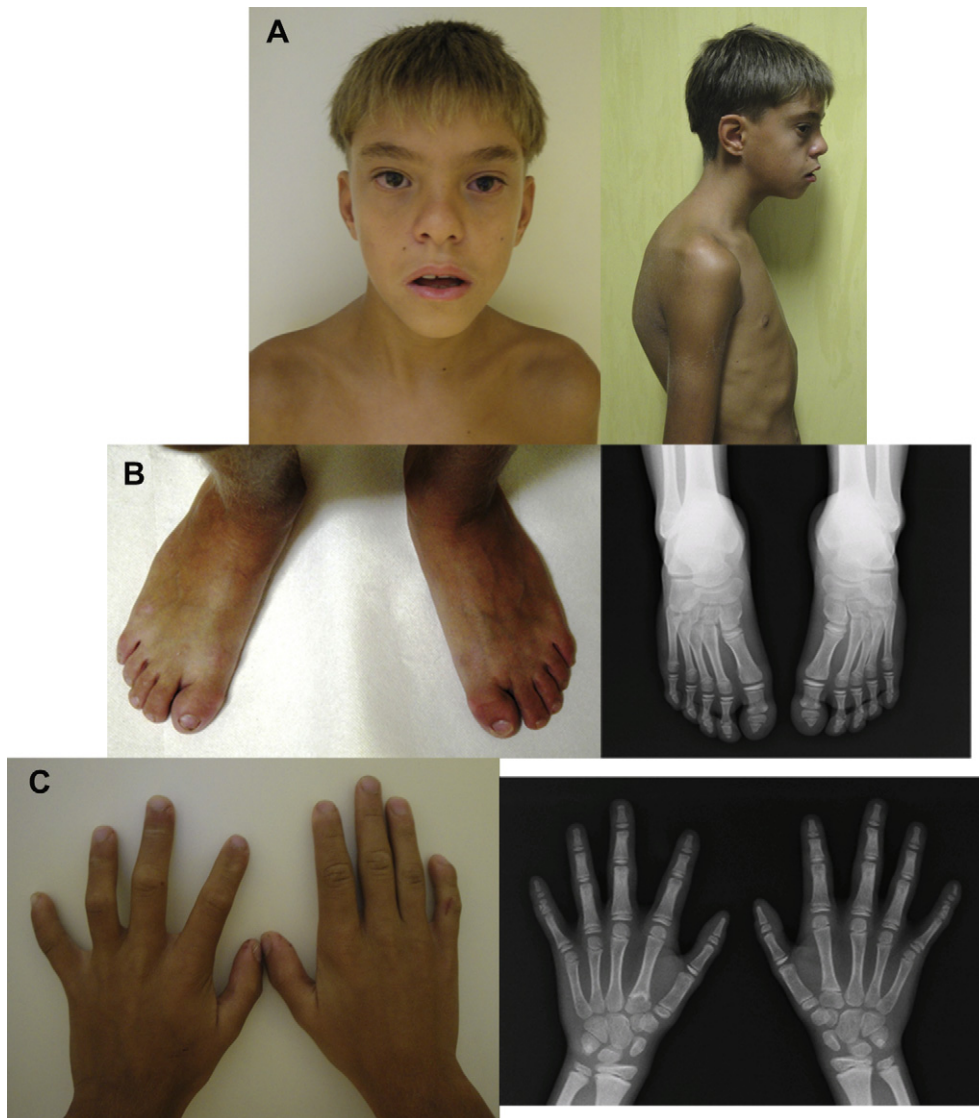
A: Face with upward slant of palpebral features, narrow palpebral fissures, palpebral ptosis and epicanthus, dysmorphic ears, thoracic deformity; B: Feet with short and stubby first toes, X-rays showing short first metatarsal bones and cone shaped distal phalanges of the 1st toes; C: Hands with low set thumbs, mild skin syndactyly, 5th finger clinodactyly, camptodactyly of the 1st, 3rd, 4th and 5th fingers of the left hand, and 2nd, 4th and 5th fingers of the right hand, X-rays showing cone shaped third phalanges of the 1st and 2nd fingers.
